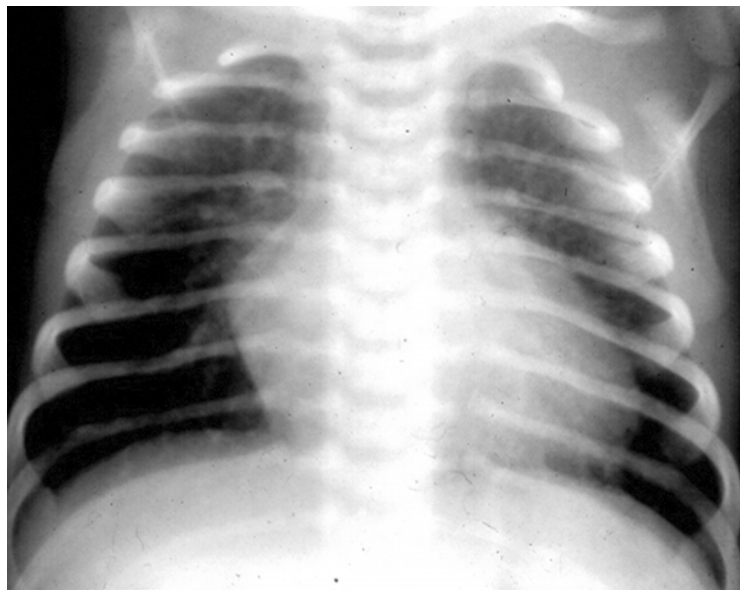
Chest radiograph of a two-day old infant with transposition of the great arteries demonstrating mildly enlarged size of the heart and increased pulmonary vascular markings.
